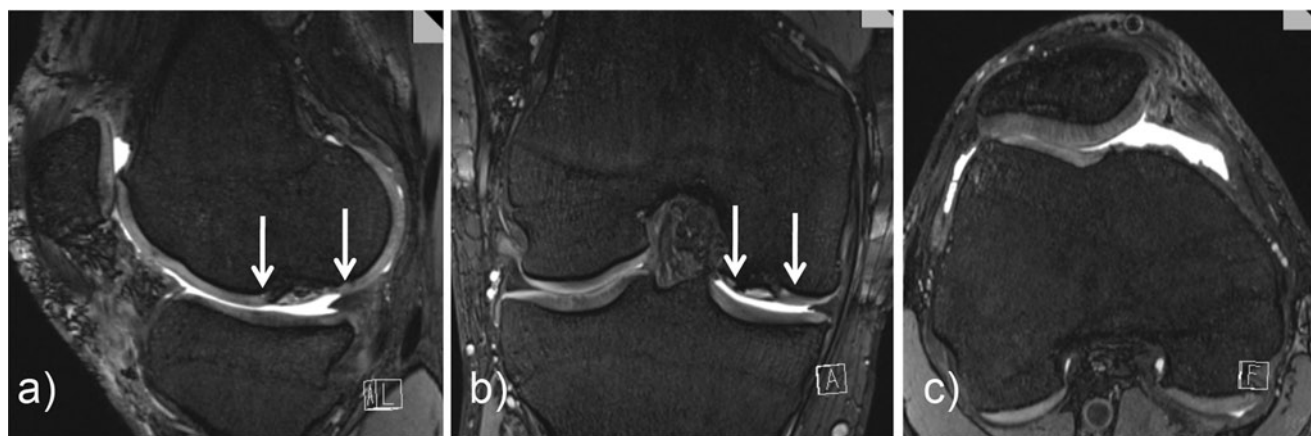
Isotropic $0.4 \times 0.4 \times 0.4 \text{ mm}$ 3D True-FISP sequence (8.9/3.8) with water excitation and high-resolution MR images reconstructed to visualize the cartilage repair tissue in a 22-year-old male patient, 3 months after MACT (arrows) in the sagittal (a) and coronal (b) planes. Additional axial (c) reconstructed images allow
